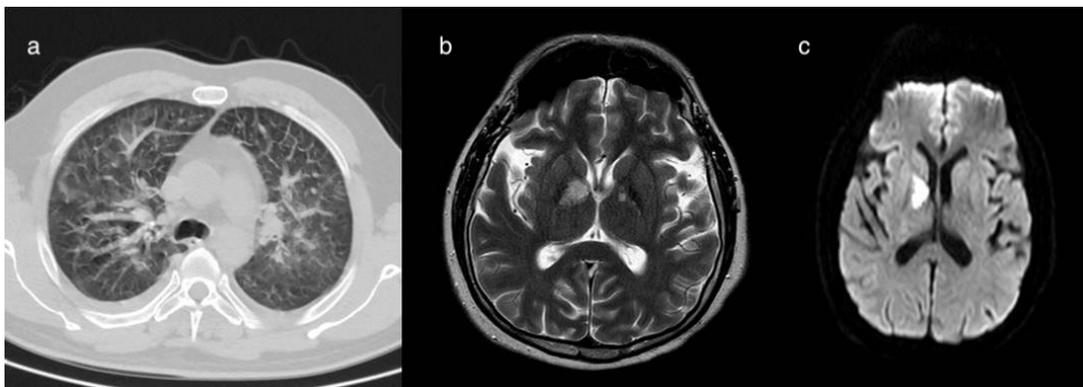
a Thoracic computed tomography at second admission, b, c Cerebral magnetic resonance imaging (MRI) and diffusion MRI
